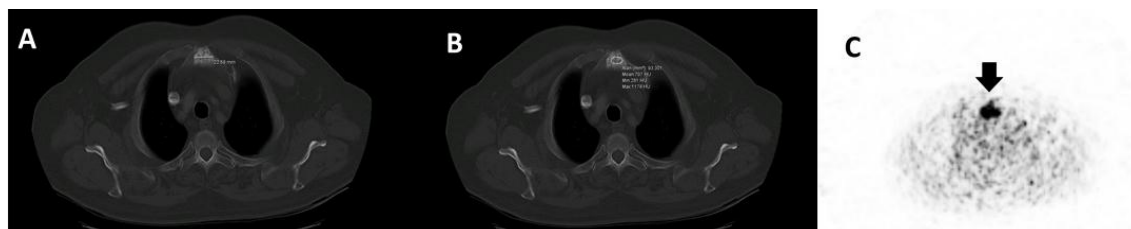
CT images of a prostate cancer case with multiple sclerotic lesions in the body and manubrium of the sternum. Figure 1A shows the measurement of the widest diameter of the lesion in the axial section, Figure 1B demonstrates the measurement of lesion density, and Figure 1C reveals the measurement of SUV_{max} as 4 on PET-CT.
